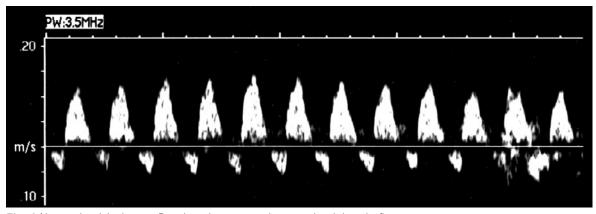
Abnormal umbilical artery Doppler velocimetry with reversed end-diastolic flow.
